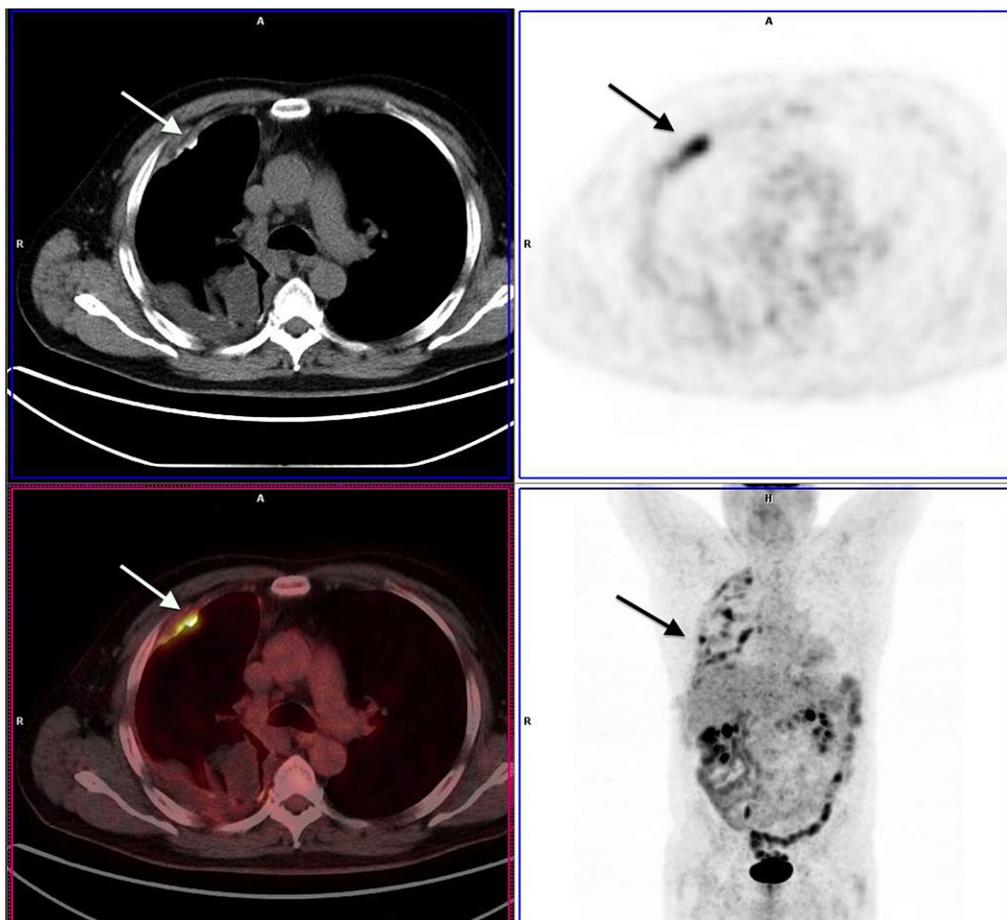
Transaxial computed tomography (CT), fluoro-deoxyglucose positron emission tomography (FDG PET), fused PET-CT and maximum intensity projection images in a patient who previously underwent talc pleurodesis. The talc can be seen as high-density material (arrow) on CT scan in the anterolateral pleural surface of the right lung. PET scan demonstrates focal FDG avidity around the talc deposition.
